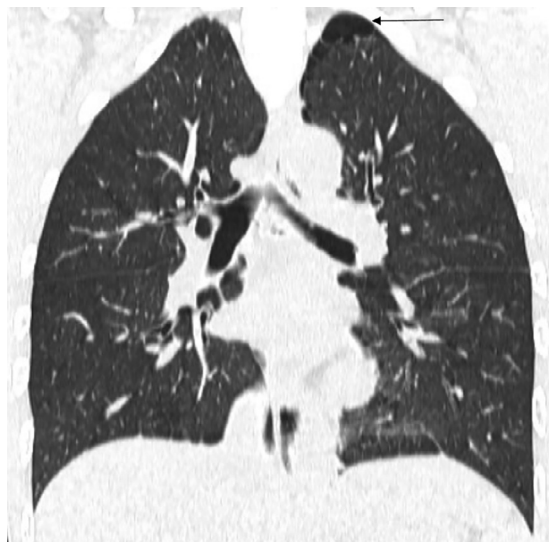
CT-scan performed the day after hospitalization showed reduction in size of the left pneumothorax with residual small amount within the apical region of the left lung (black arrow).
